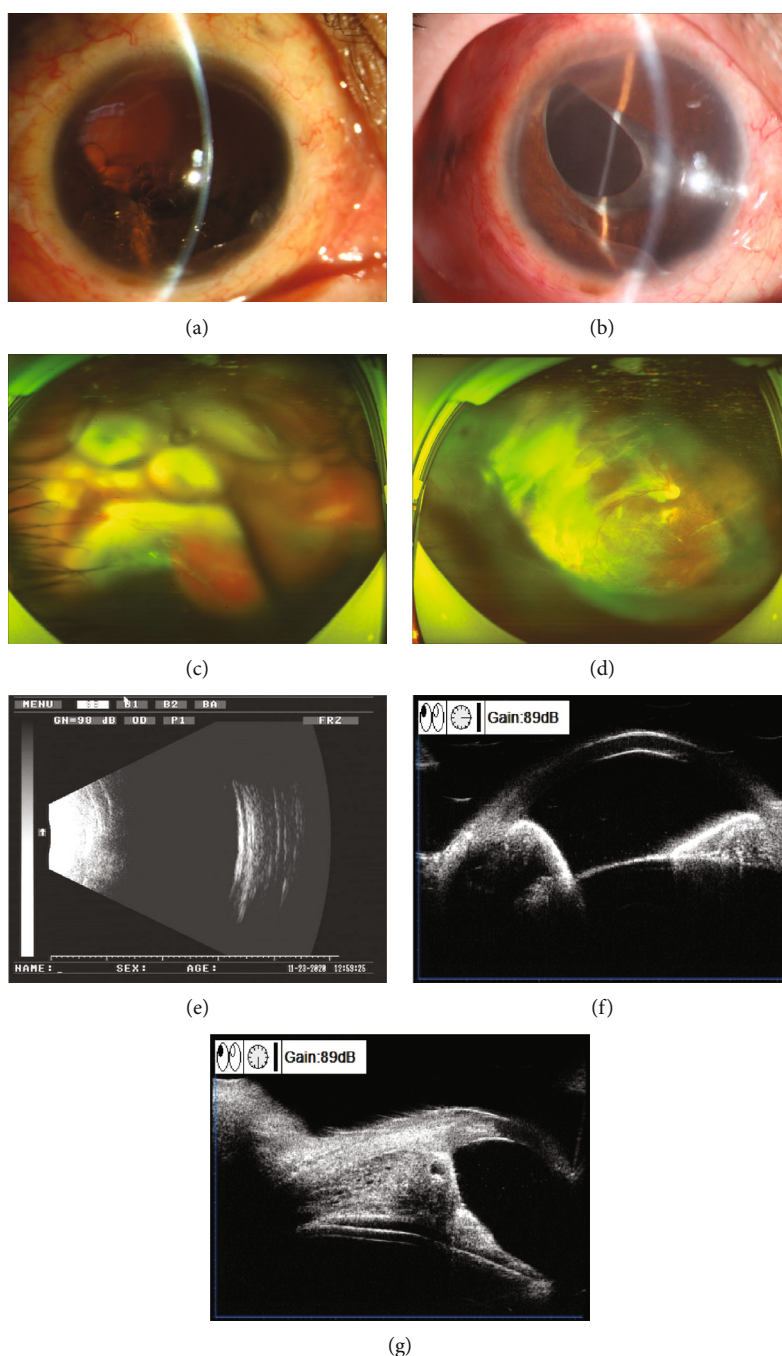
Examination results before and 12 months after FCVB implantation in stage II eyeball rupture. (a) Preoperative anterior segment photography revealed that the vitreous cavity was filled with SO, and the SO moved into the anterior chamber. The cornea was clear; most of the iris and crystal were absent. (b) Anterior segment photography at 12 months after surgery revealed that the cornea was clear, the anterior chamber was not shallow, part of the iris and the lens were absent, and FCVB was in place in the vitreous cavity. (c) Preoperative fundus photography showed retinal folds and extensive retinal detachment. (d) Fundus photography at 12 months after surgery displayed that the retina was flat. (e) B-ultrasound at 12 months after surgery showed the reflection of the posterior wall of the eyeball as smooth, and the FCVB shape as intact. (f, g) UBM at 12 months after surgery showed approximately normal anterior chamber depth, with opened chamber angle, and smooth front surface of FCVB.
